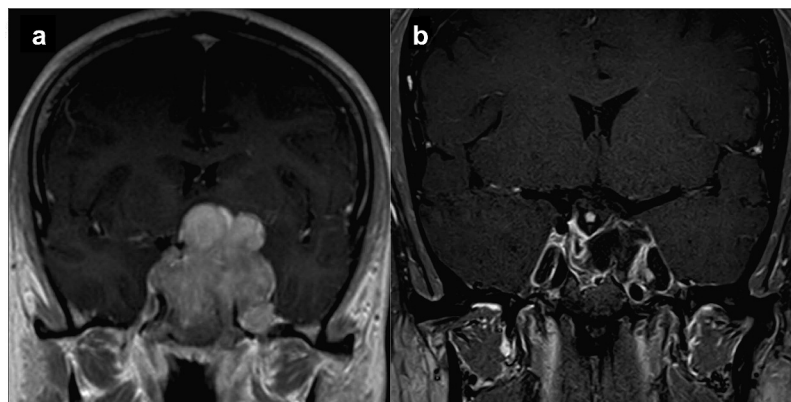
A) Giant prolactinoma is an 18 year old male with a serum prolactin > 20,000 ng/ml, bitemporal hemianopsia, and hypopituitarism. MRI demonstrates a large mass with bilateral Grade 4 cavernous sinus invasion. B) Treatment with cabergoline resulted in normalization of prolactin and massive tumor regression with restoration of vision in 6 weeks. No surgery was performed. It is unlikely initial surgical resection would have benefitted the patient.
